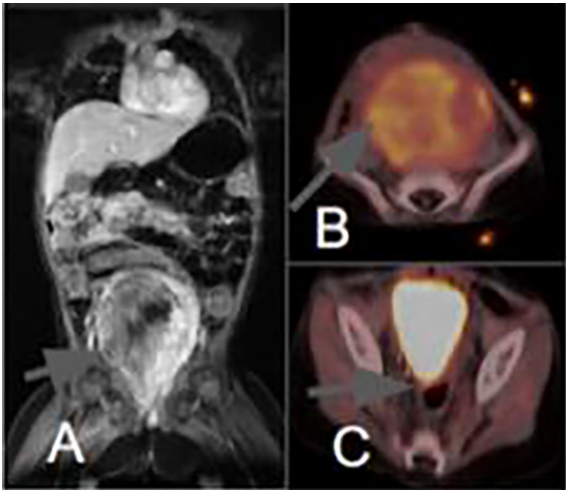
A. Preoperative MRI showing a large prostatic tumor displacing the iliac vessels laterally. B. PET-CT prior to surgery, confirming metabolic activity. C. Postoperative PET-CT: Indicating no metabolic activity.
